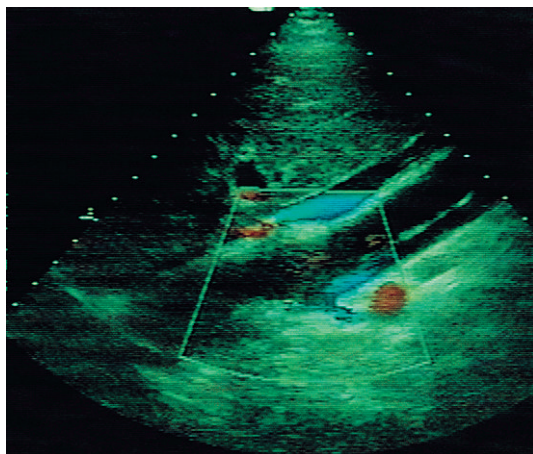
Colour flow Doppler examination of the aorta in a case of aortic dissection. There is reverse flow in the false lumen which modifies flow within the left renal artery. The reverse flow is demonstrated (in blue) underneath the linear echogenic dissection flap. From Dubbins³³, with permission.
